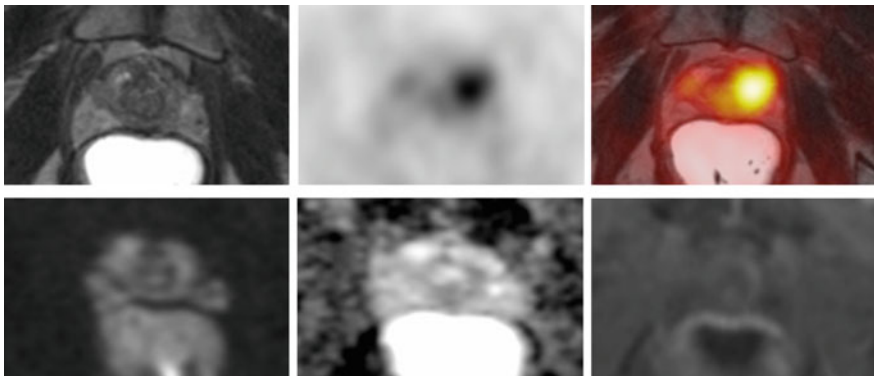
Detection of MP-MRI occult prostate cancer by Ga-68-PSMA-11 PET/MR in a patient with elevated PSA (9.2) and a negative prostate biopsy. MP-MR images of the prostate (T2 weighted, diffusion-weighted, ADC map and T1 contrast enhanced) shows no evidence of prostate cancer (PIRADS score 1). In contrast, there is intense tracer uptake in the left prostate, consistent with malignancy. Prostate cancer (Gleason 4 + 3) was confirmed by targeted biopsy
